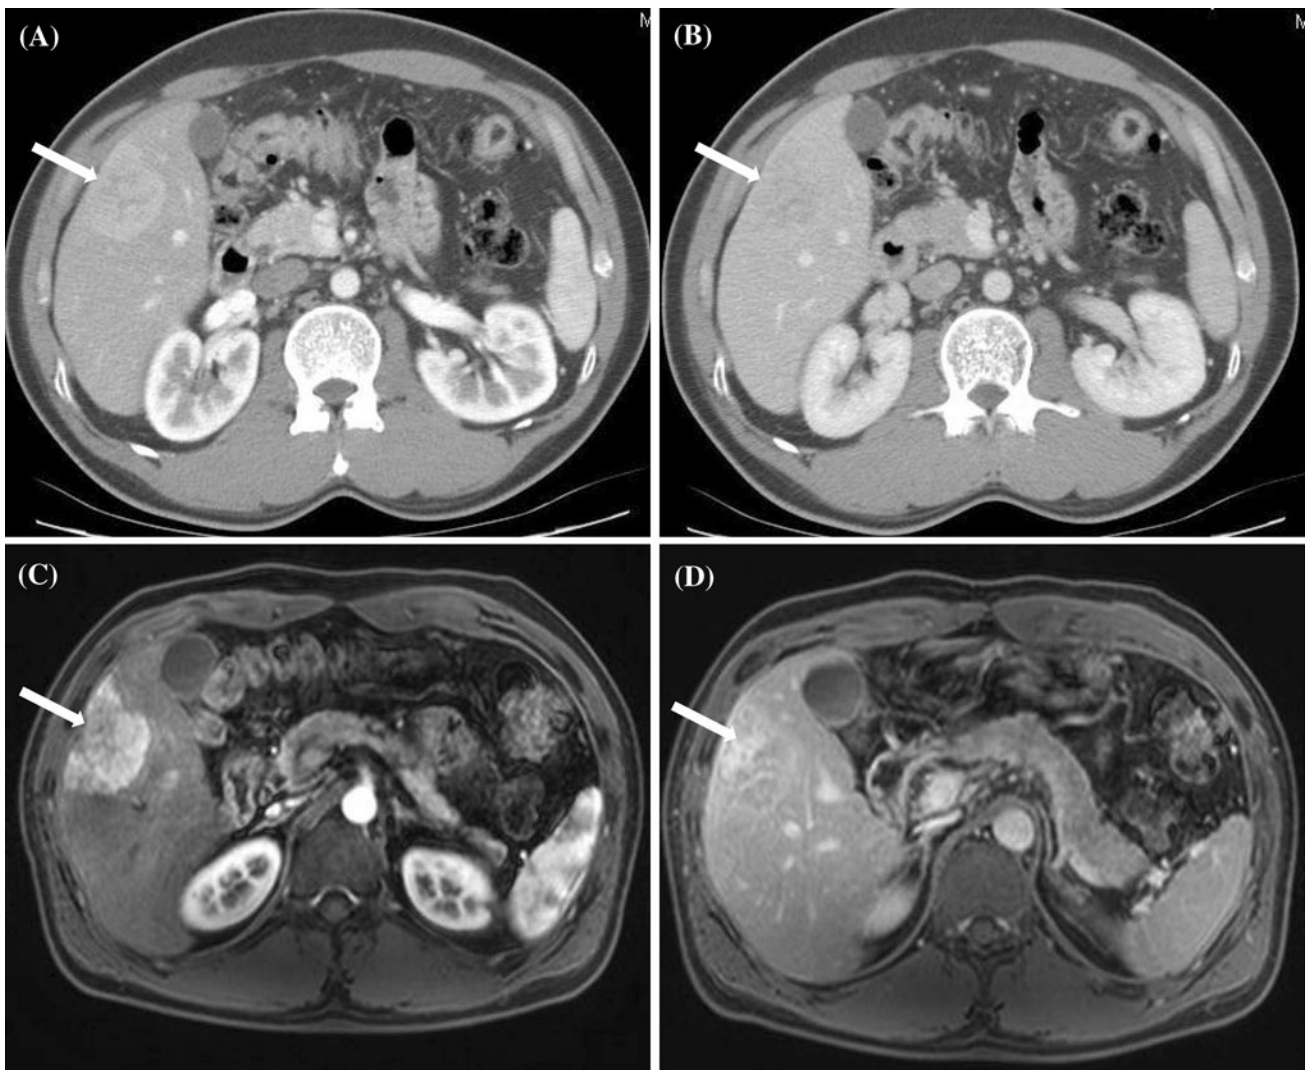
Image findings of a 56-year-old male with a 5-cm scirrhous hepatocellular carcinoma (HCC) (*arrow*). CT images show a peripheral subtle enhancement of the tumor in the arterial phase (a) and a hypoattenuating lesion on the central portion in the delayed/portal phase (b). MRI findings also showed similar imaging patterns. In
